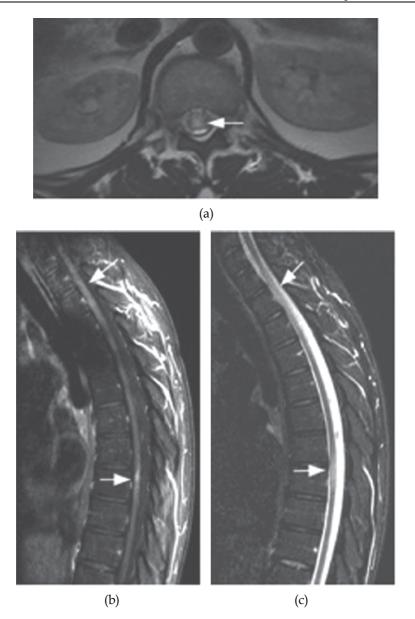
Intramedullary sarcoidosis. (a) A 27-year-old male with sarcoidosis. Axial T2weighted image at the level of the conus medullaris shows an area of increased signal intensity within the conus (arrow) representing intramedullary involvement. (b) A 27year-old male with systemic sarcoidosis presented with paraplegia. A T2-weighted sagittal image shows patchy increased signal intensity within the spinal cord at the C7-T2 level as well as T6-T7 level (arrows) and (c) a sagittal gadolinium-enhanced T1-weighted image shows abnormal enhancement of these lesions (arrows), representing intramedullary involvement.
